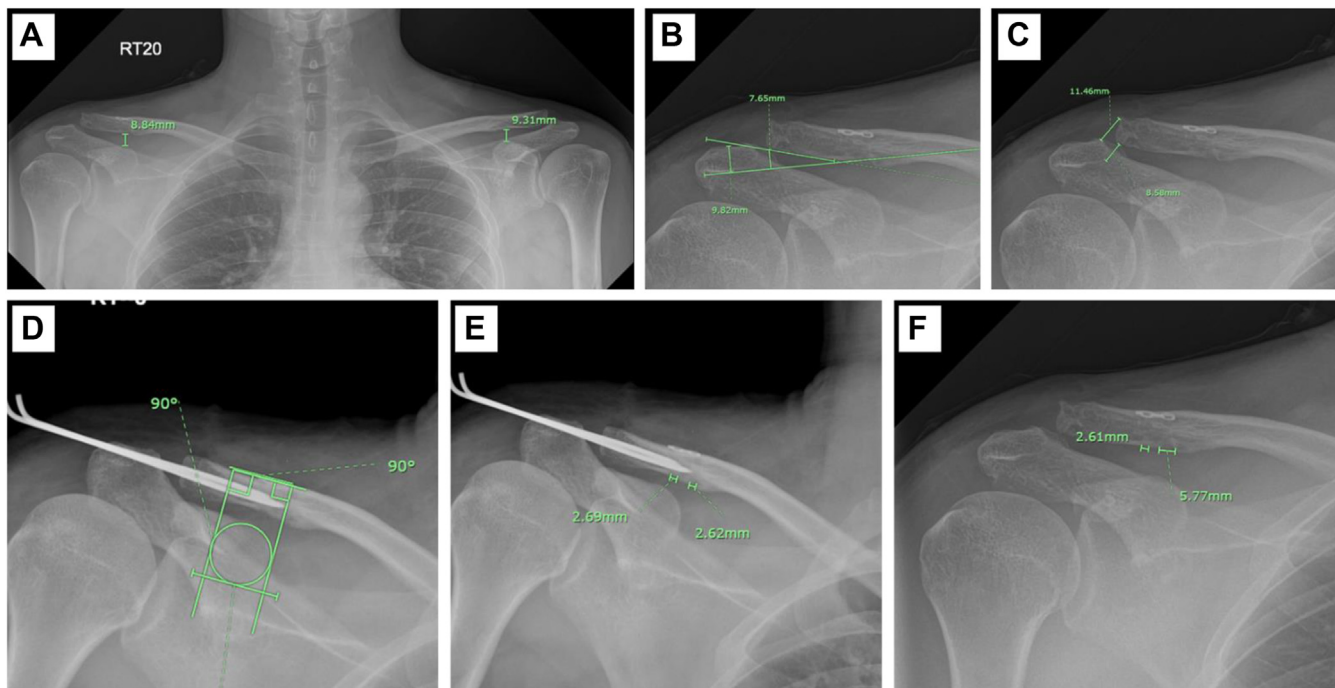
The radiographic measurement parameter in the study. (A) CCD measurement in both shoulders. (B) AC subluxation ratio measurement of the right shoulder. (C) AC joint widening measurement of the right shoulder. (D) Tunnel position measurement of the right shoulder. (E) An immediate postoperative measurement of clavicular tunnels of the right shoulder. (F) The final follow-up measurement of the clavicular tunnel of the right shoulder. CCD, coracoclavicular distance; AC, acromioclavicular.
